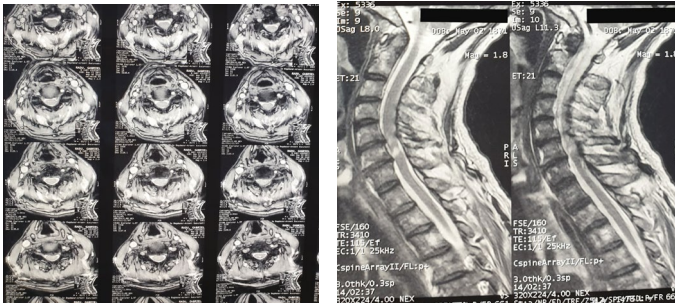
Cervical MRI-axial
